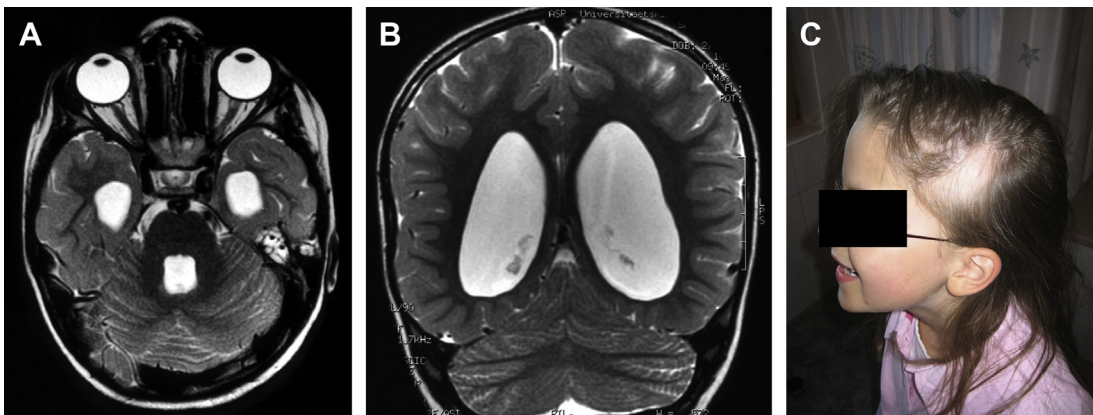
GLH syndrome. (A) Axial and (B) coronal T2-weighted images showing RS with keyhole appearance of fourth ventricle, fusion of the cerebellar hemispheres without an intervening vermis, as well as fusion of the dentate nuclei and superior cerebellar peduncles. (C) 10-year-old girl with GLH syndrome showing alopecia in the left scalp.
